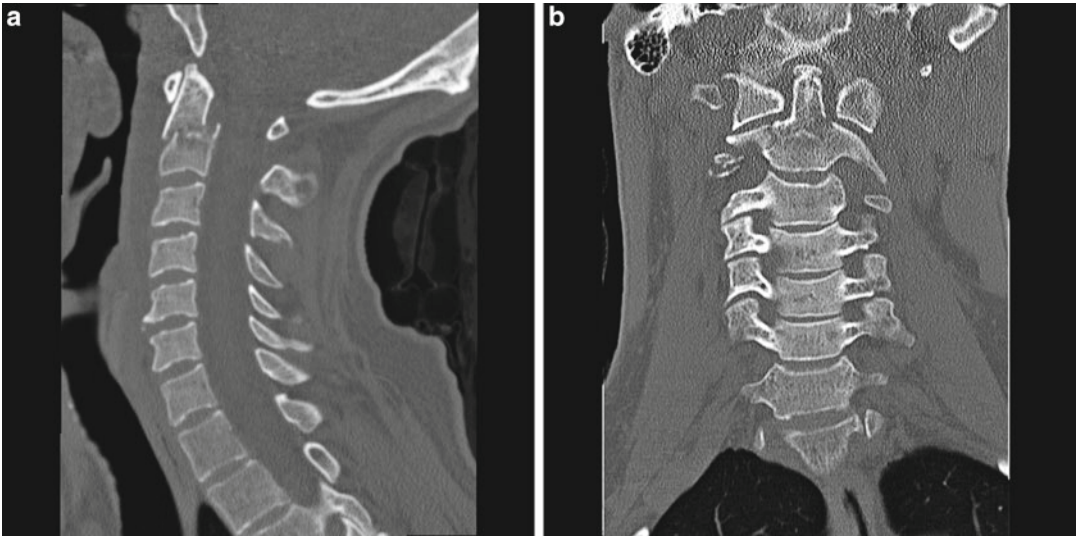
Sagittal (a) and coronal (b) CT scan demonstrating a type III odontoid fracture with 7.5 mm of anterior translation
